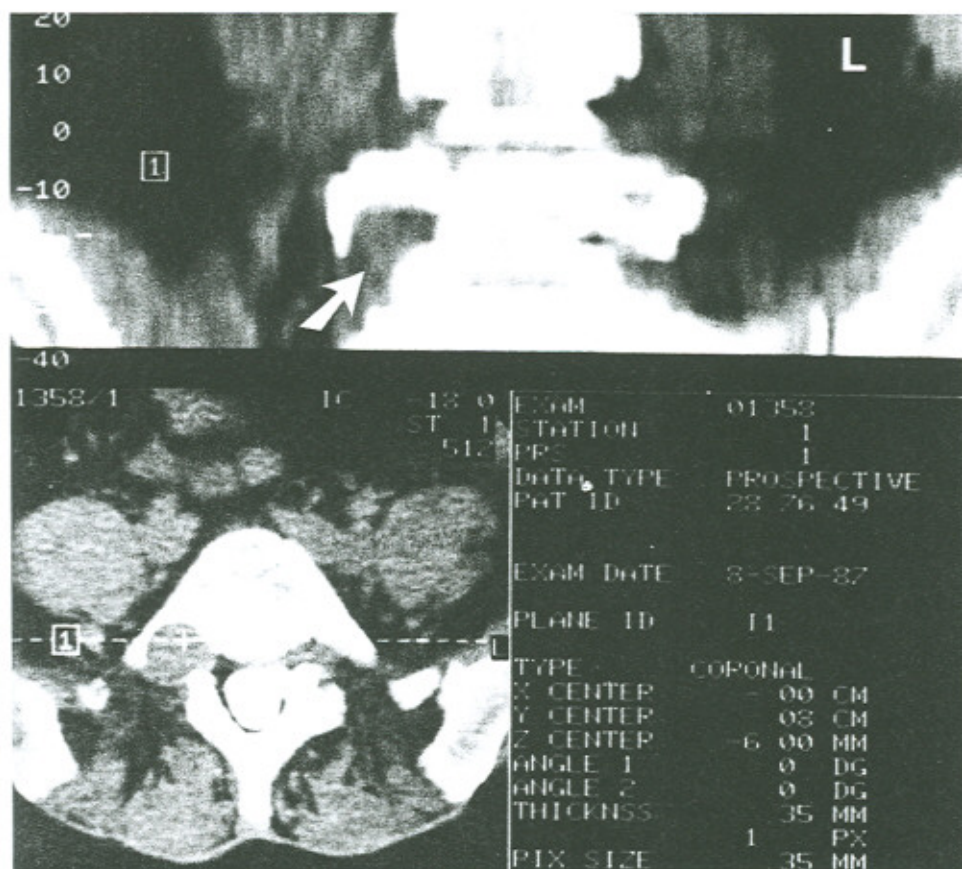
A CT scan of the patient in figure 1. In the axial section, a large soft tissue mass can be seen in the lateral canal (lower left). In the coronal reconstruction, the enlarged lateral recess (arrow) is appreciated when compared to the left side.
